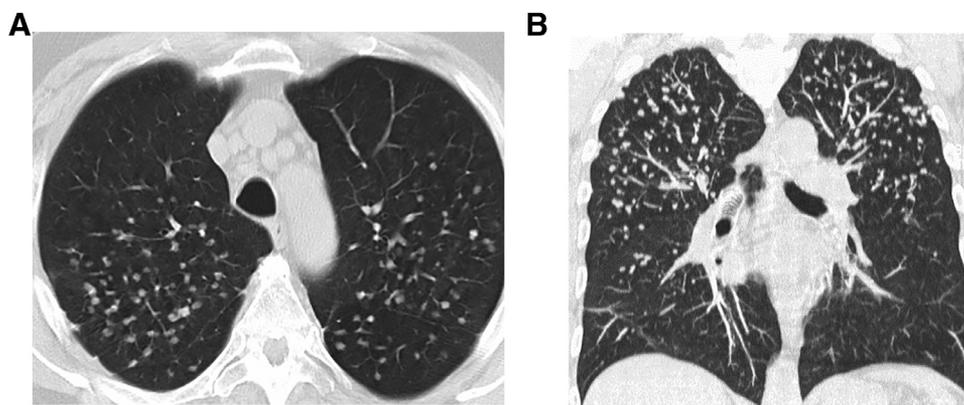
Sarcoid reaction in young male with RA treated with etanercept. Axial and coronal reformatted CT images show upper lobe predominate perilymphatic nodules. RA, rheumatoid arthritis.
